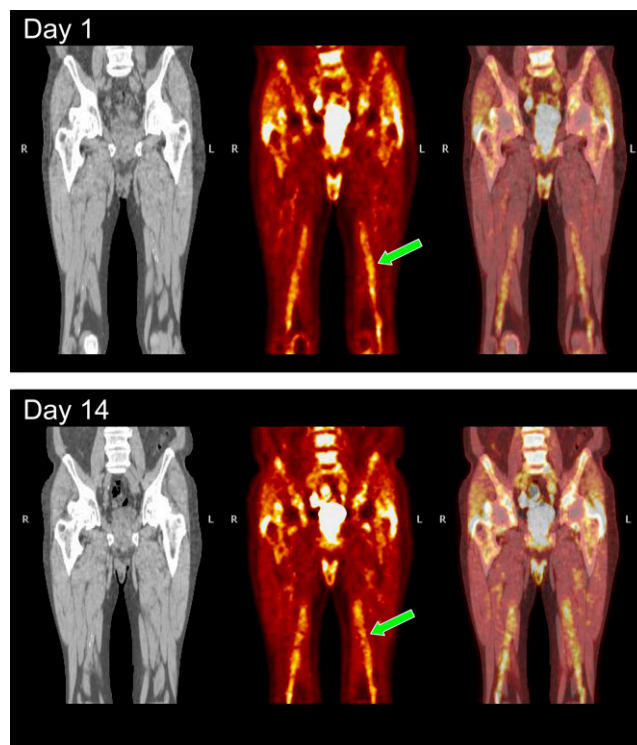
Coronal CT (left), ^{18}F -FDG PET (middle), and fused PET/CT (right) images of femoral artery territory at day 1 and day 14. Scans were separated by 2 wk. Note little change in amount of ^{18}F -FDG uptake in femoral artery between 2 scans. Arrows on ^{18}F -FDG PET images highlight femoral artery ^{18}F -FDG accumulation.
